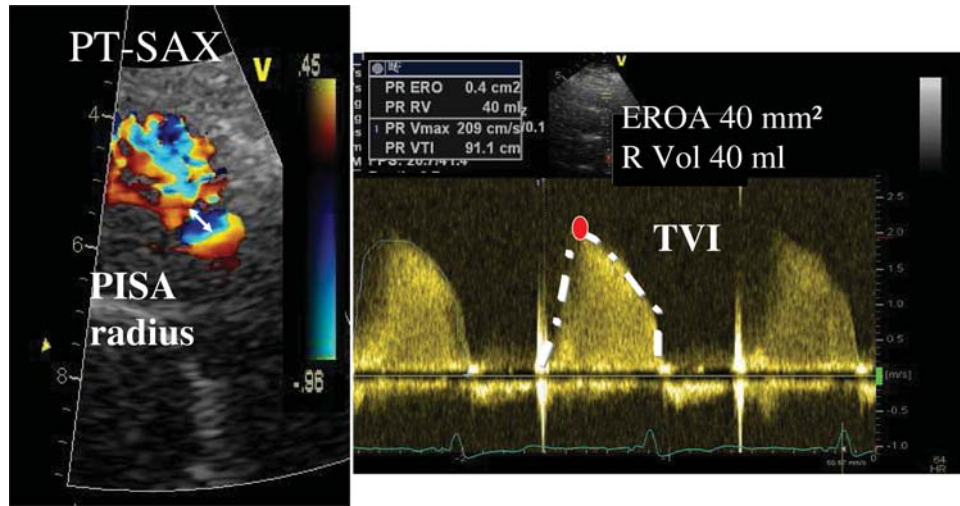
Assessment of pulmonary regurgitation by the proximal isovelocity surface area (PISA) method. PT-SAX, parasternal short-axis view; EROA, effective regurgitant orifice area; R Vol, regurgitant volume.
